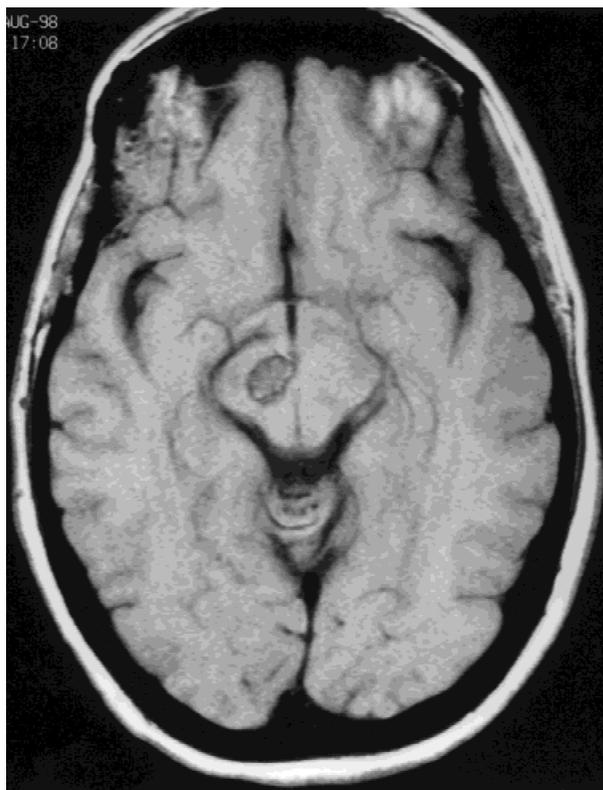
Brain magnetic resonance imaging (MRI) scans demonstrating low signal intensity lesion on T1 and high signal intensity lesion on T2, consistent with a cavernous hemangioma in the right anterior midbrain.
